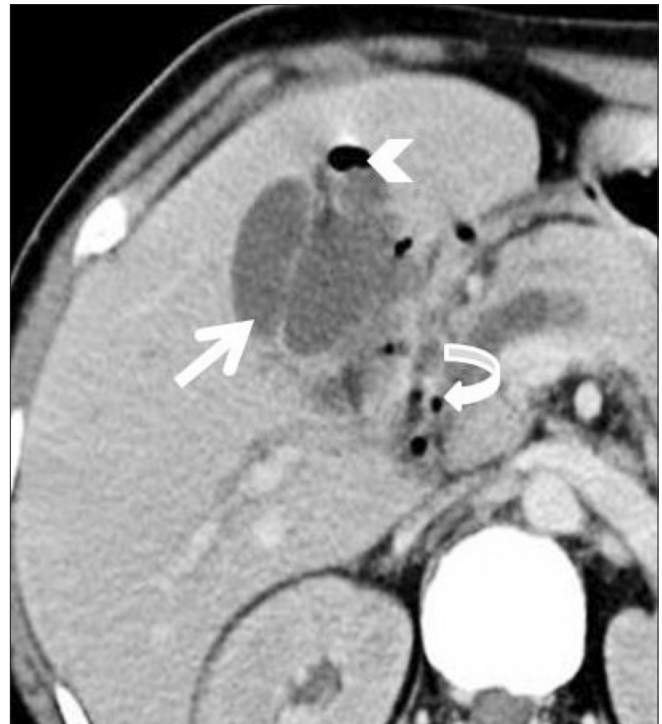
Axial CT scan shows intrahepatic abscess (arrow), with a focus of air (arrowhead). Also note foci of free intraperitoneal air (curved arrow)
